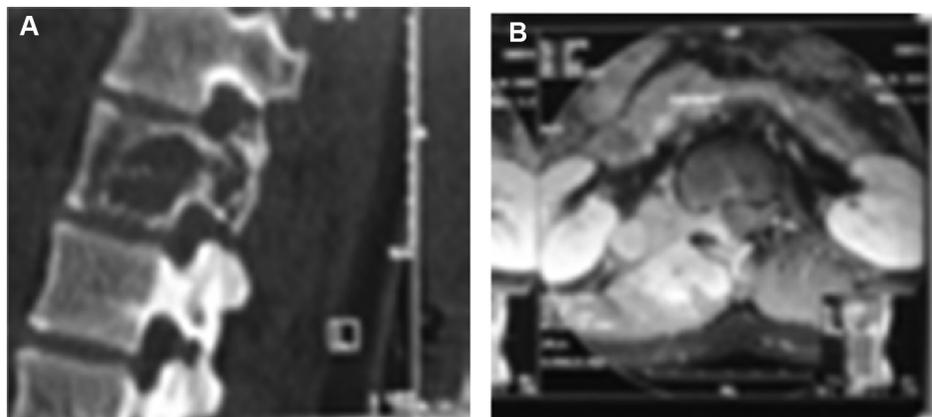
CT scan showing the destruction of the L1 vertebra with pedicular involvement. (A) represent pathology in sagittal section and (B) represent the same pathology in Axial view of CT scan. CT = computed tomography.
